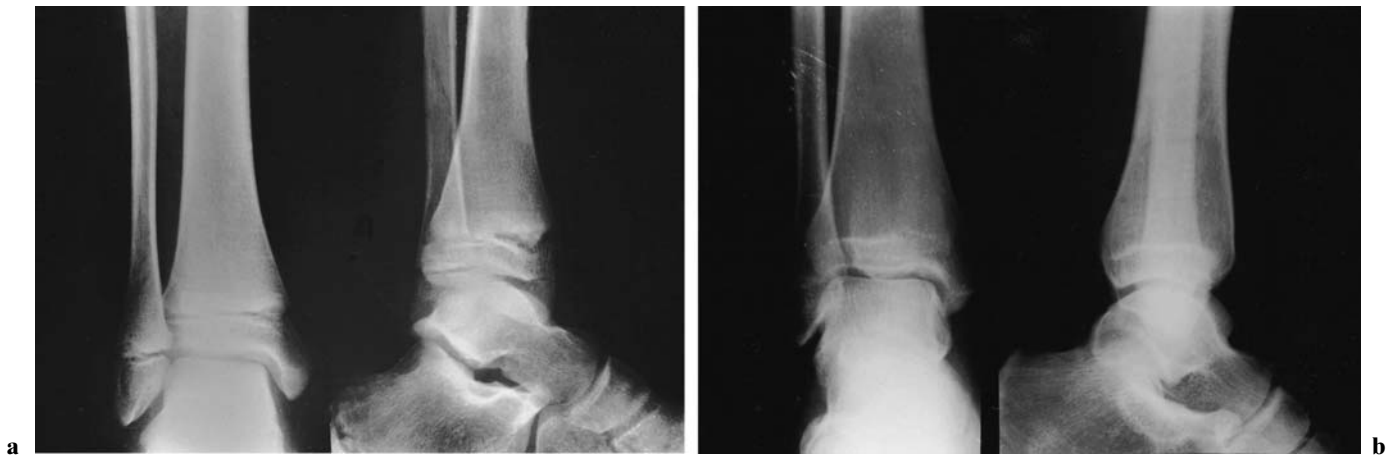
a Rotational injury of the distal tibial physis of a boy aged 13. Irregularity and widening of the growth plate is present in the anteroposterior radiograph. In the lateral view a spiral fracture of the distal fibula is just obvious, and we can
